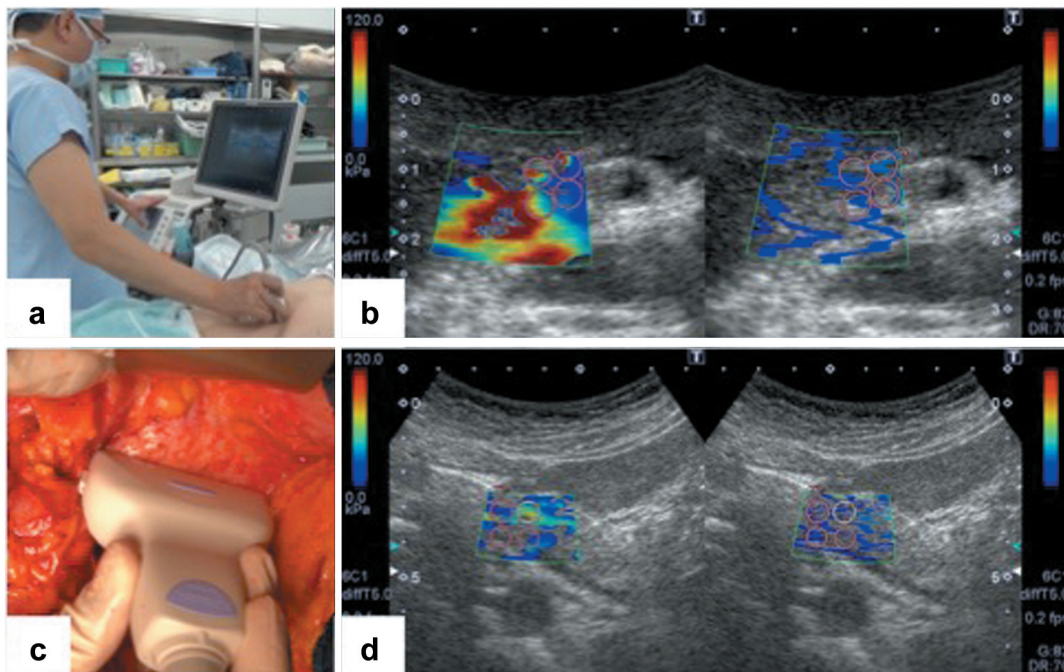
Measurement of pancreatic shear wave elastography (SWE). *a.* Preoperative measurement of SWE from the body surface. *b.* Ultrasonographic findings of preoperative SWE. *c.* Intraoperative measurement of SWE by attaching the probe directly to the pancreatic parenchyma. *d.* Ultrasonographic findings of intraoperative SWE.
